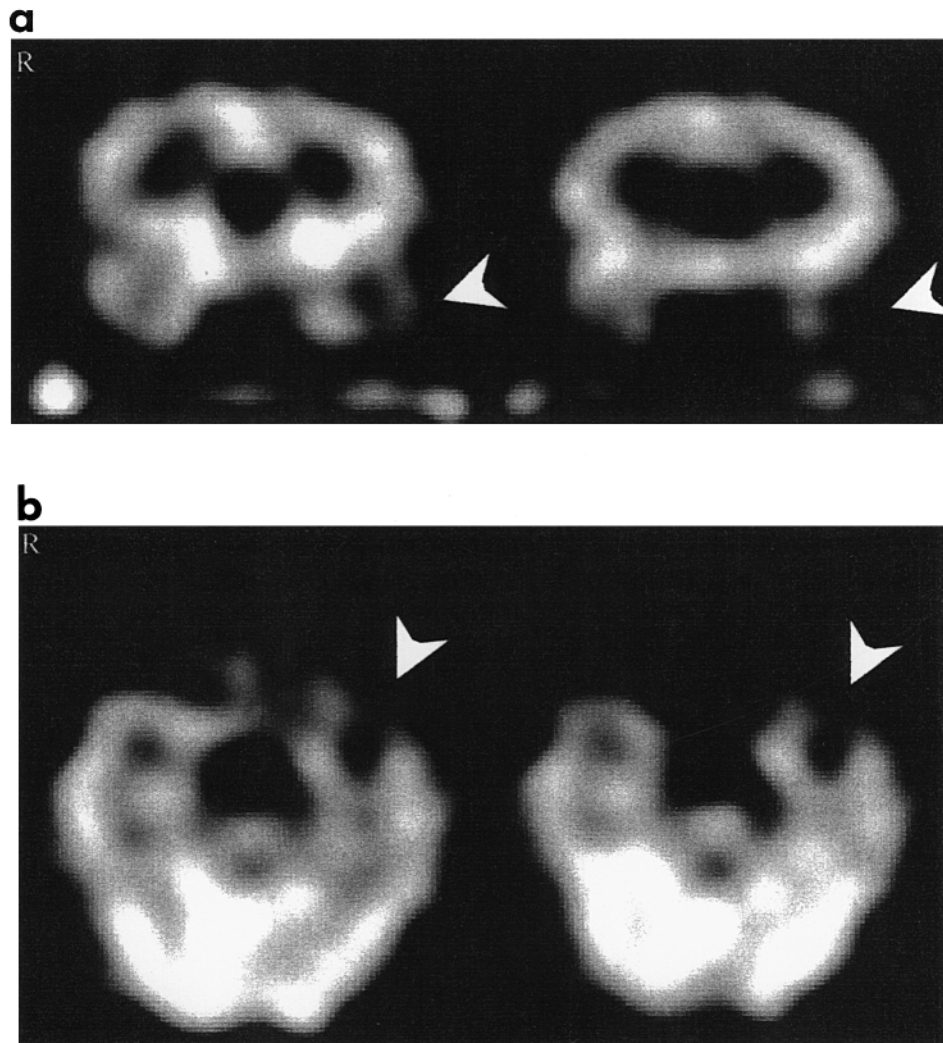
SPECT scan with Hm-PAO (1992) demonstrating a mild focal decrease in cerebral blood flow at the left temporal pole (arrows). (a) shows two coronal sections through the temporal lobes, while (b) shows horizontal sections through the temporal lobes.
